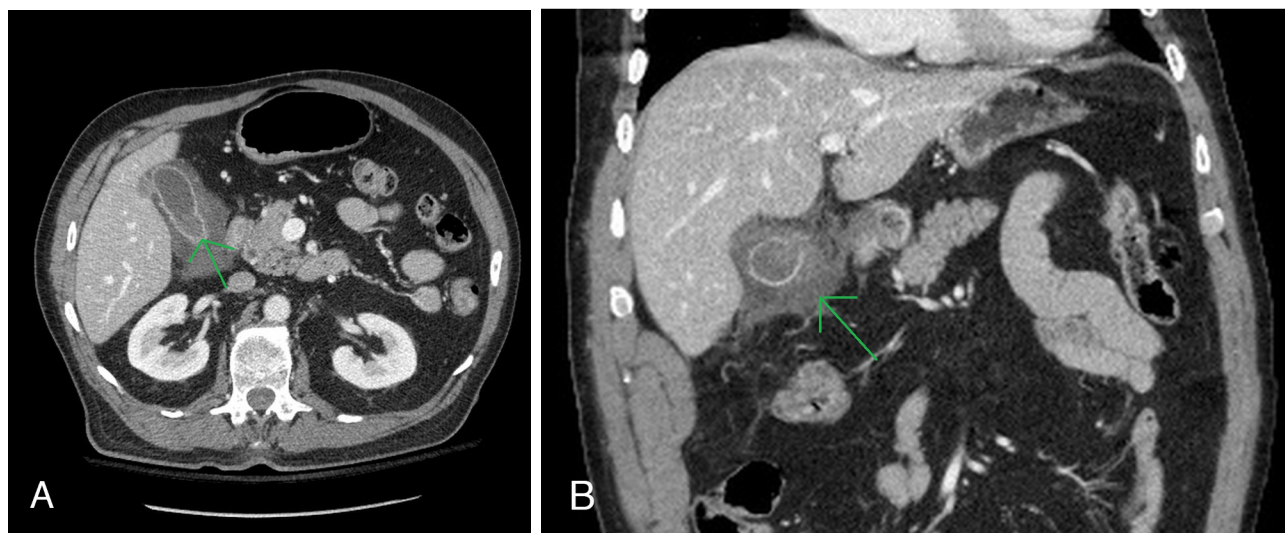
A and B. 59-year-old male with perforation of the gallbladder. Findings: Axial (A) and coronal (B) contrast-enhanced CT images of the abdomen through the gallbladder reveal wall thickening and focal mural disruption. Technique: Selected axial and coronal CT images of the abdomen and pelvis with IV contrast.
